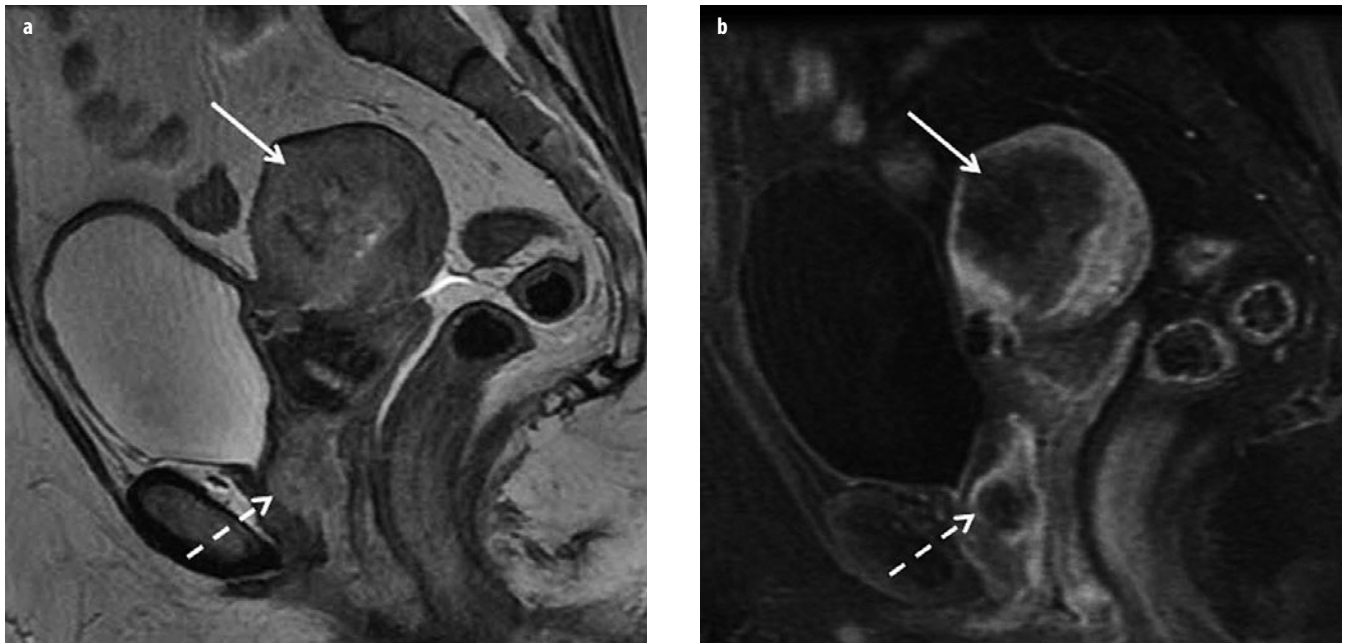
a, b. a Sagittal T2-weighted and b sagittal contrast-enhanced T1-weighted images of a stage IIIB endometrial cancer with >50% myometrial depth invasion (*solid arrow*), as well as vaginal “drop” involvement (*dashed arrow*)
